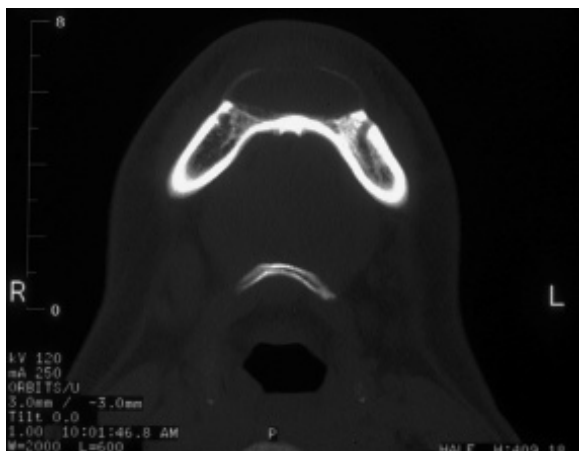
Marsupialization of a syndromic KOT will result in shrinkage of the lesion, and ultimately requiring an enucleation and curettage of the lesion. (a) The CT scan identifies a large multilocular radiolucency that crosses the mandibular midline. (b) Two 14-French red rubber catheters were placed in the lesion following suturing of the lesion's epithelium to the oral mucosa.
